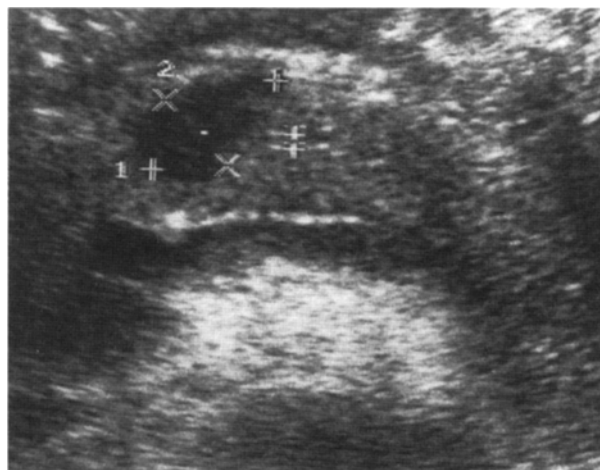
Ultrasound showed an isolated round pancreatic lesion of low echogenicity within the corpus of the gland (1: 2.4 cm; 2: 1.5 cm).
